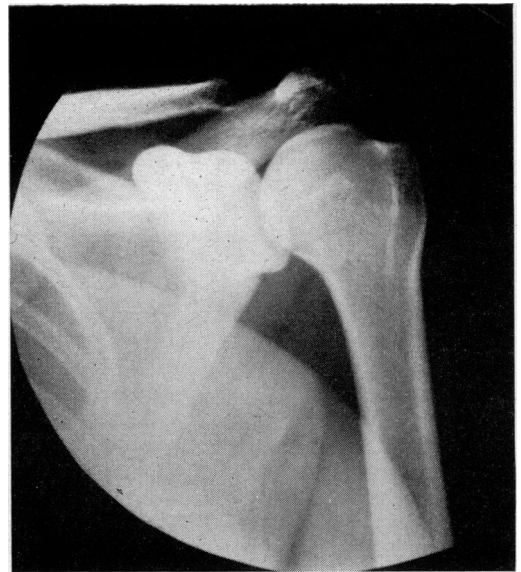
X-ray changes in acromioclavicular joint*
